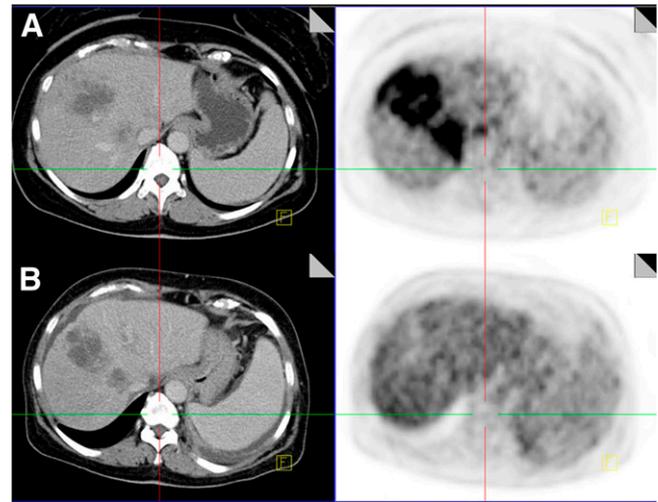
Axial slices of CT (left) and fused PET/CT (right) scans before therapy (A) and after therapy (B) demonstrating large liver metastases. SUV_{max} decreased markedly (–73%) after radioembolization, indicating therapy response, whereas tumor size as measured with CT did not change significantly.
